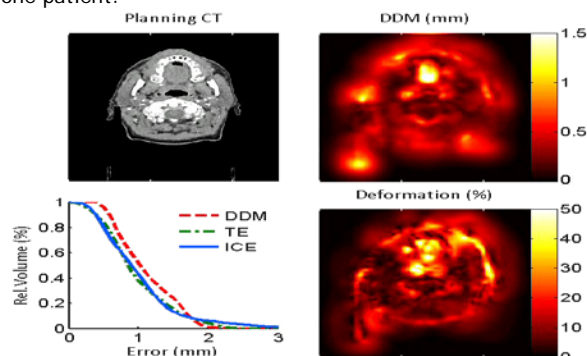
Axial cross section of a planning CT, distance discordance metric (DDM) and tissue deformation of a representative patient. The error volume histograms show the DDM, transitivity error (TE), and inverse consistency error (ICE) of the body contour.
